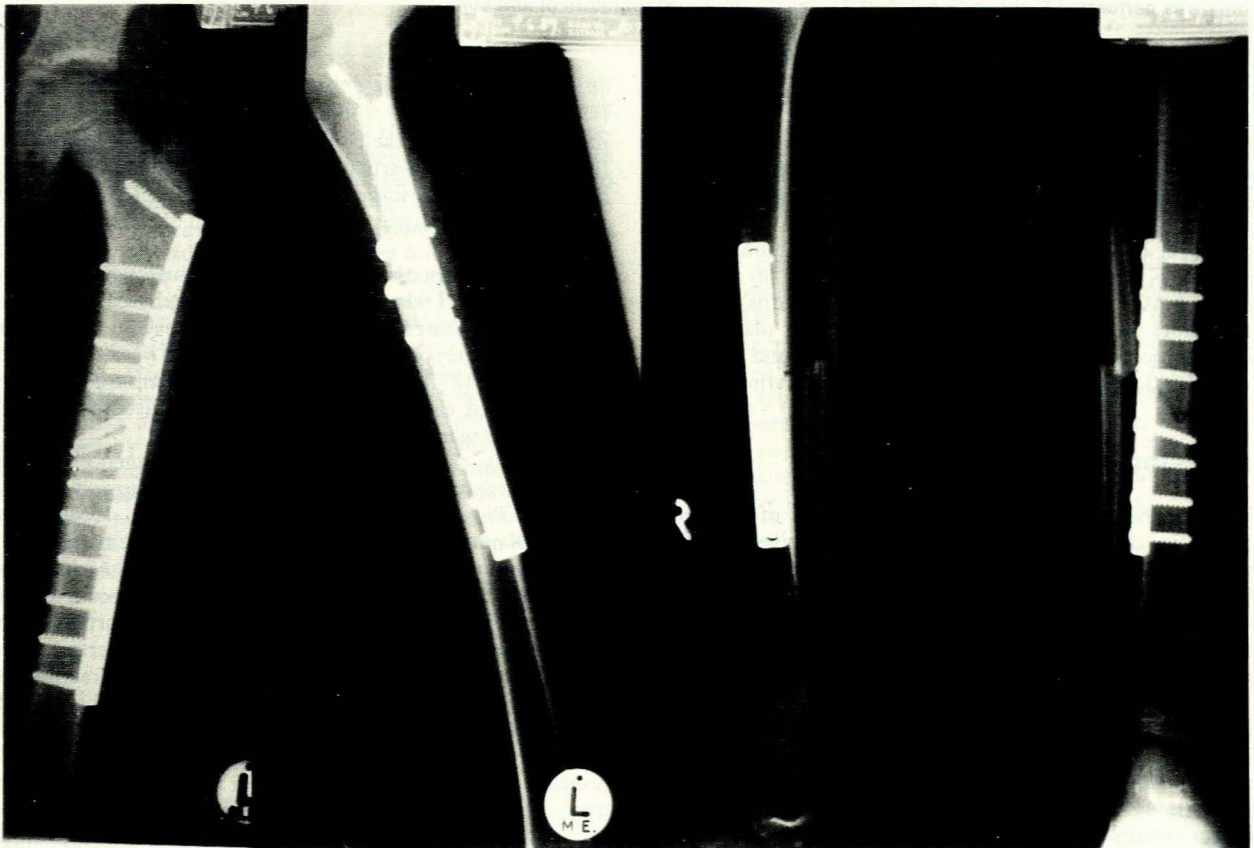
Radiographs of injuries of contralateral limbs in a polytraumatised boy (age 6 years). Early callus production is visible. Early mobilisation was achieved.
